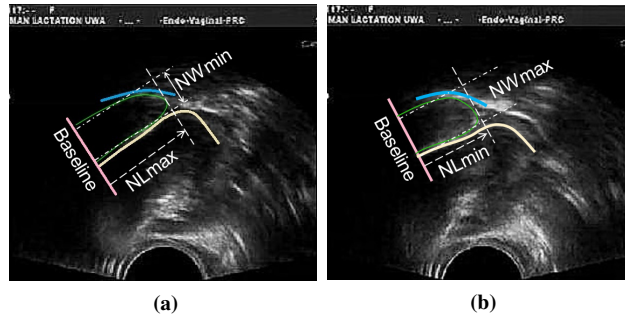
Nipple dimension measurement with Ultrasound images: (a) Tongue moving up, and (b) Tongue moving down.
